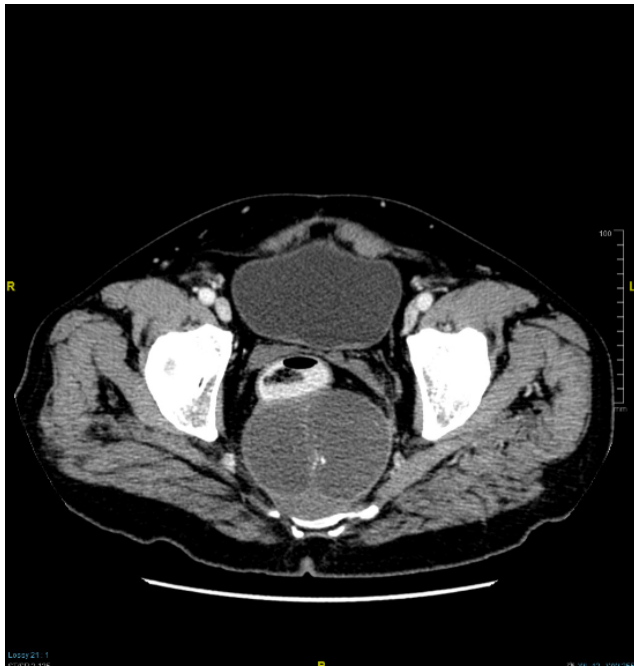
CT ABDOMEN.mucin,enhancing soft tissue post.Se107.Img1
